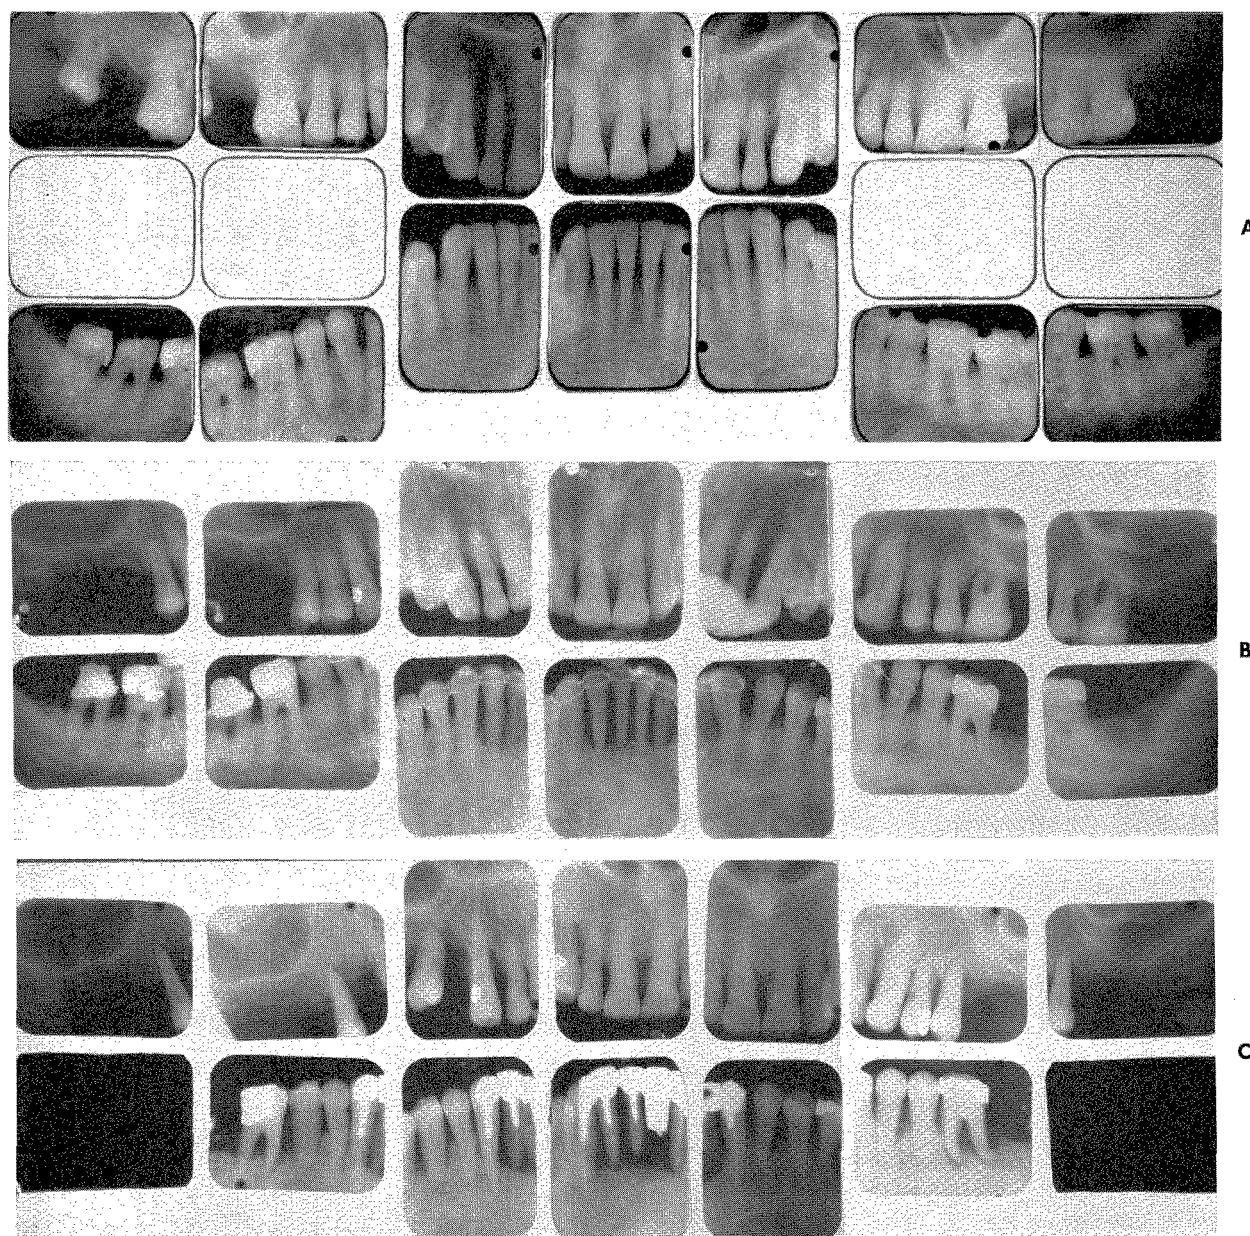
A, Roentgenograms taken in September, 1944, of a male patient 47 years old. B, Roentgenograms taken in February, 1957. Severe periodontal involvement. C, Roentgenograms taken in April, 1962. The periodontal disease continued unchecked in spite of specialized treatment.
